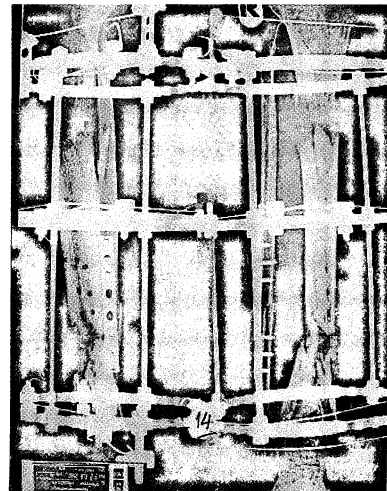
Anteroposterior and lateral roentgenogram showing that internal lengthening of the tibia has progressed toward bridging of the non-union gap.
